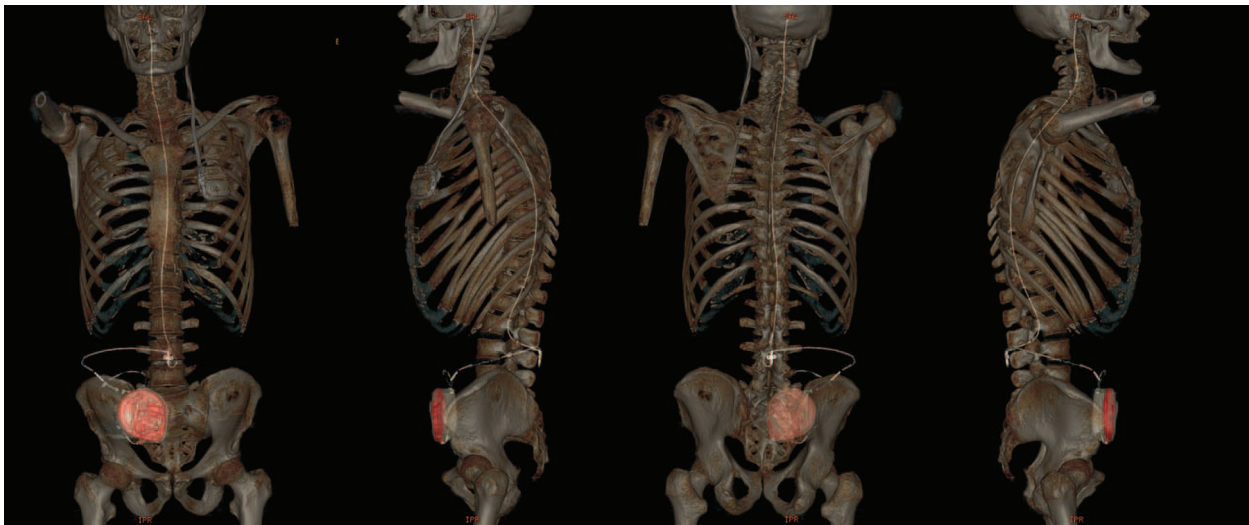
3D high-resolution CT reconstruction with the system in place. The tip of the catheter is seen at the level of the cisterna magna. 3D=three dimensional, CT=computed tomography. Source: Author.
